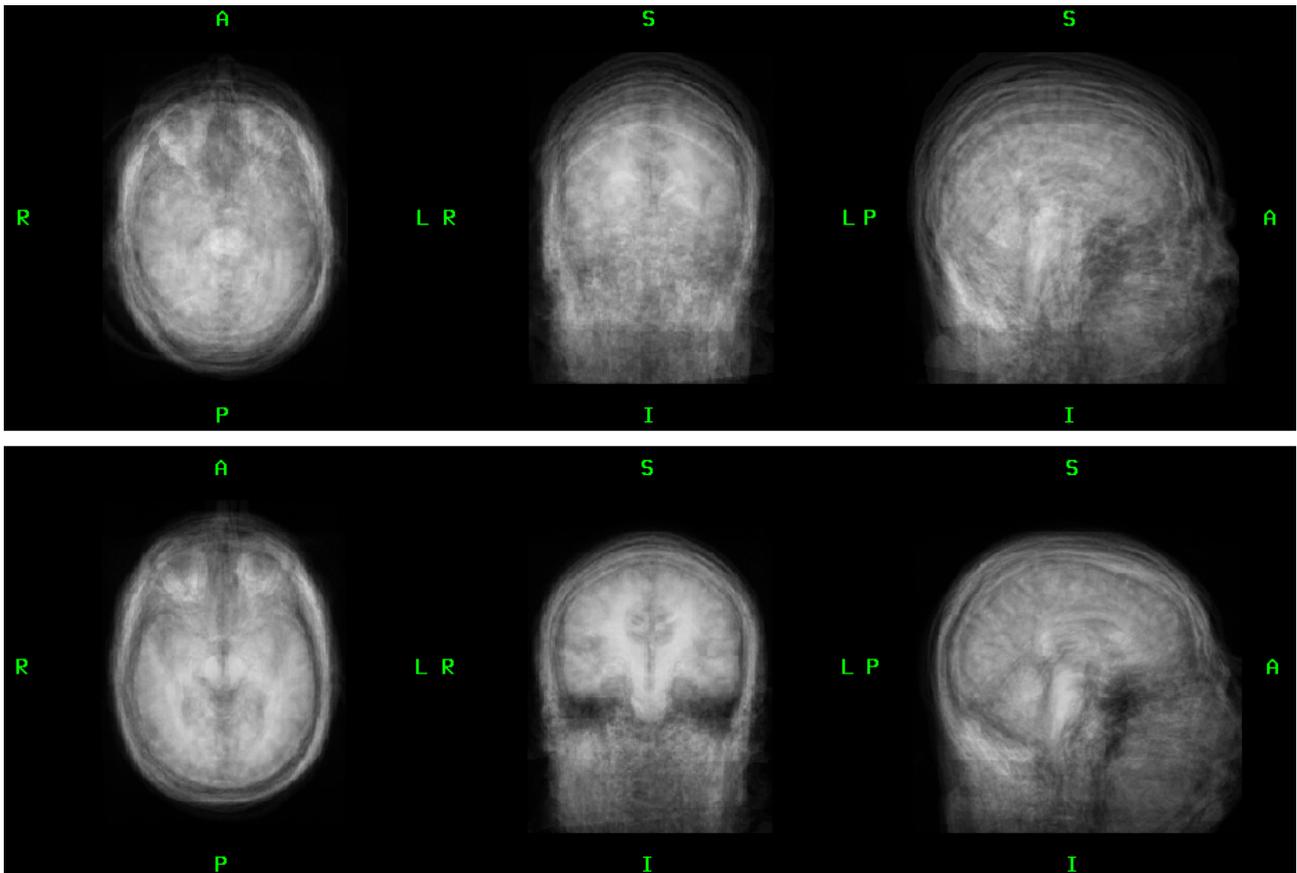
T1-weighted images (n=19) superimposed before (top) and after (bottom) positional normalization
